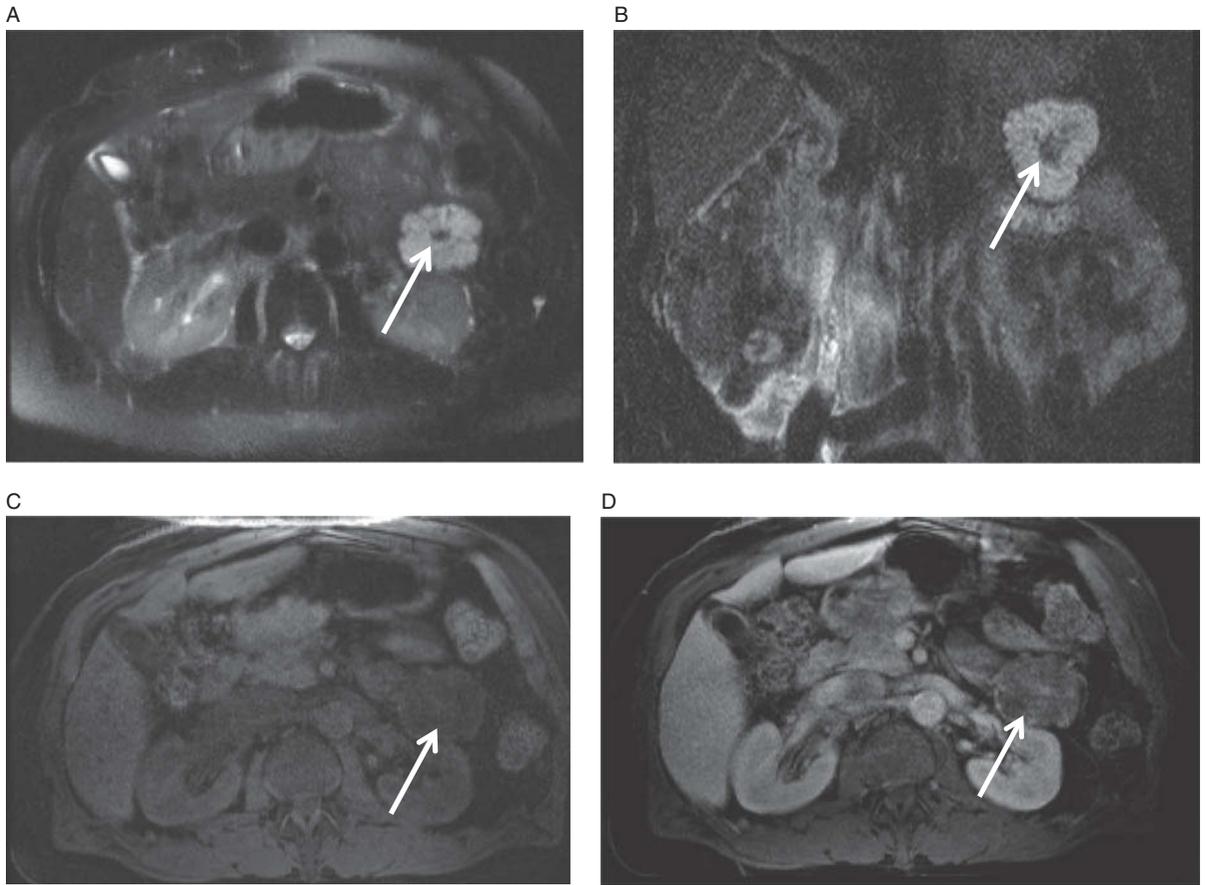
Serous cystadenoma. Axial and coronal T2-weighted images (A, B) demonstrate a multicystic lesion within the tail of the pancreas. Arrows indicate dark signal compatible with central calcification. Axial, T1-weighted, fat-saturated pre- and post-contrast images (C, D) demonstrate internal septal enhancement (arrows).
